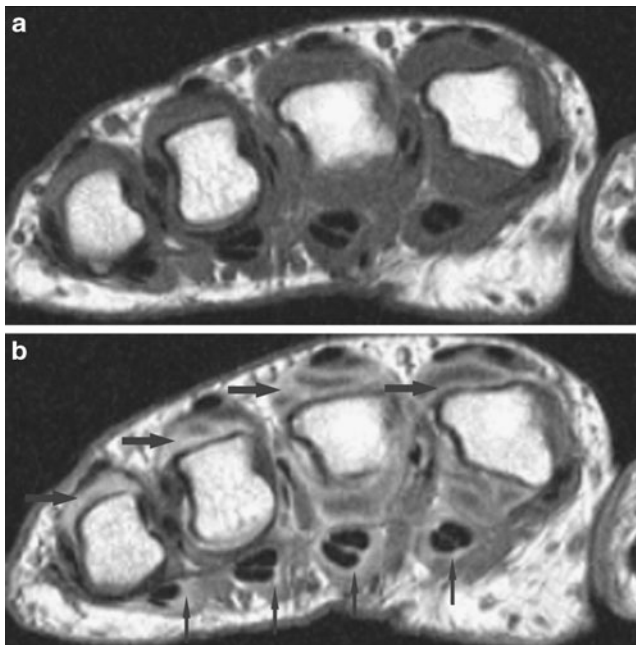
MRI to detect (teno-)synovitis in a patient with early rheumatoid arthritis. Axial T1SE sequence of the second to fifth metacarpophalangeal joints in a patient with early rheumatoid arthritis before (a) and after (b) intravenous contrast agent injection. Severe synovitis is seen in all metacarpophalangeal joints (*horizontal arrows*). Flexor tendon tenosynovitis is also noted, particularly at the second and third finger (*vertical arrows*). Courtesy Susanne J. Pedersen, MD, Copenhagen
